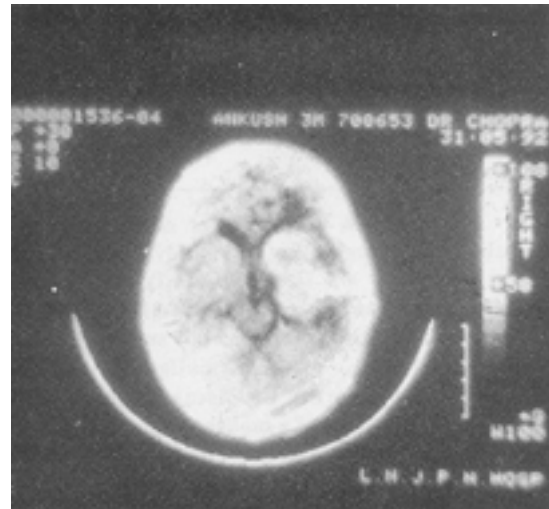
CT scan done after 3 months showing decrease in the lesion size
